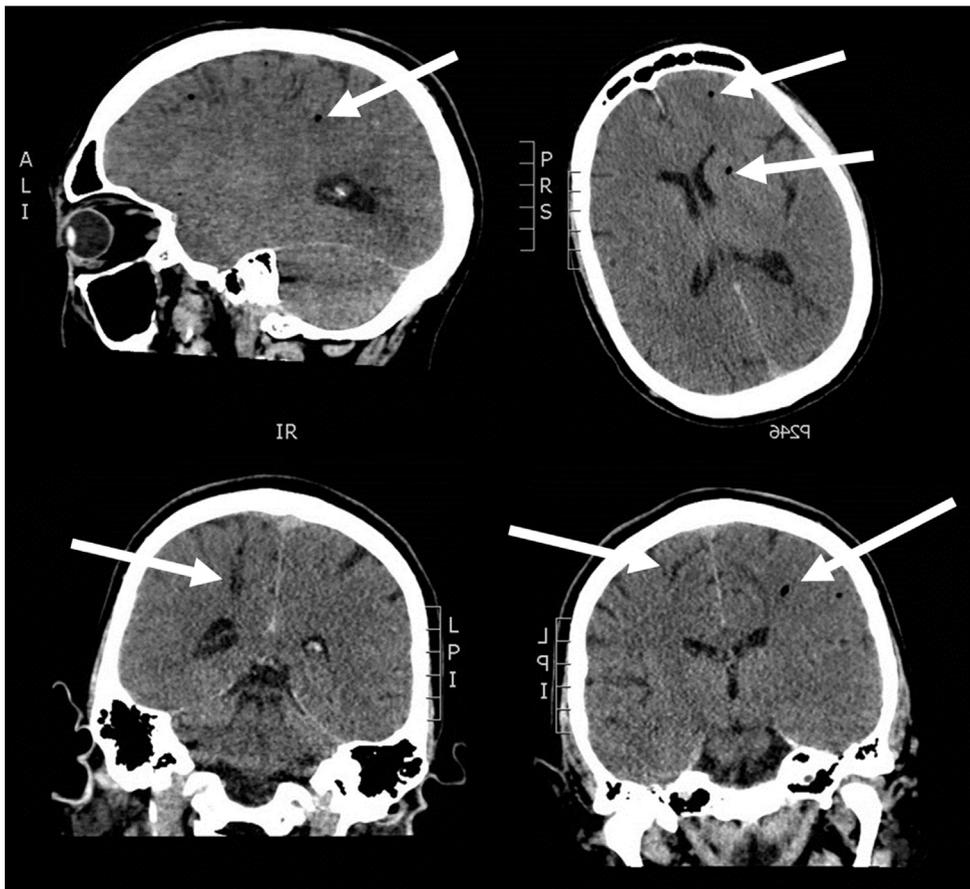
Non-contrast head computed tomography (CT) scan at the initial emergency department visit showing multiple foci of pneumocephalus (white arrows). Although present in both hemispheres, the gas had a greater effect on the right hemisphere (based on CT and subsequent magnetic resonance imaging).
